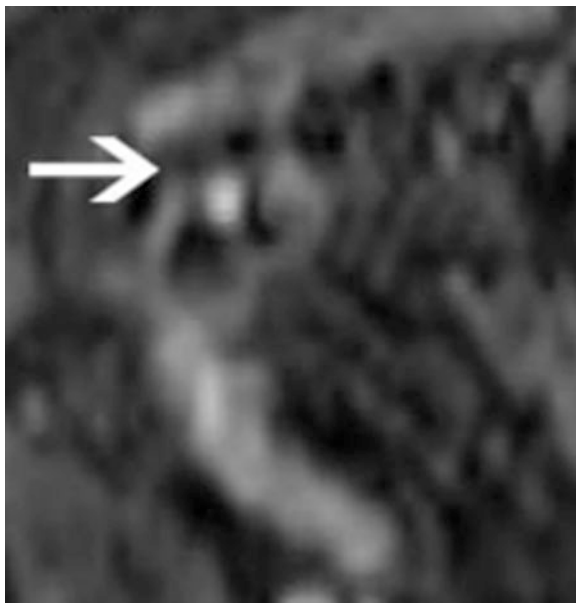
Dark lumen MRC: Axial reformatted of coronally acquired T1-weighted SPGR with twofold acceleration using ASSET showing an intensely enhancing cecal adenoma (*arrow*)
